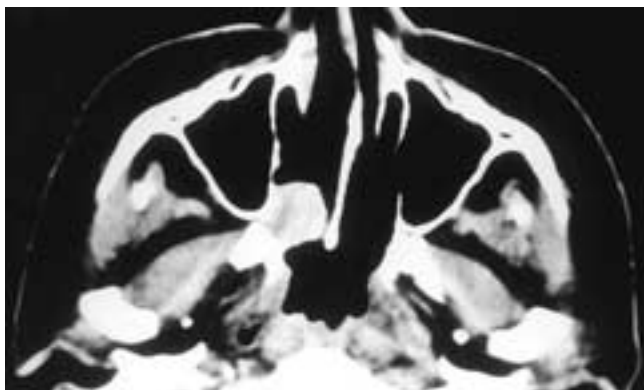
Axial CT scan shows a small polypoid mass along the right posterior lateral nasal wall. There is no associated bone erosion. This patient had an extrasosseous plasmacytoma.
